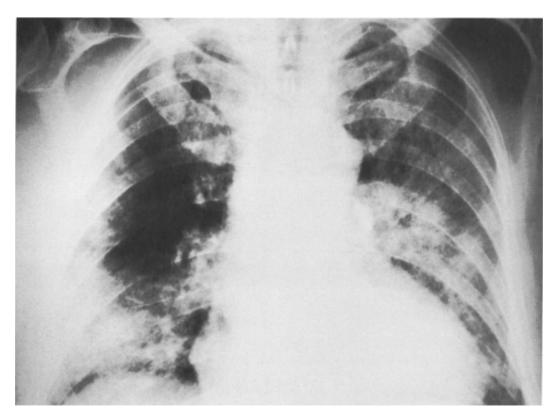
Lung changes following organophosphate poisoning with insecticide. A chest radiograph taken after hospital admission demonstrates a combination of alveolar and interstitial pulmonary edema. The heart shadow is markedly enlarged.
